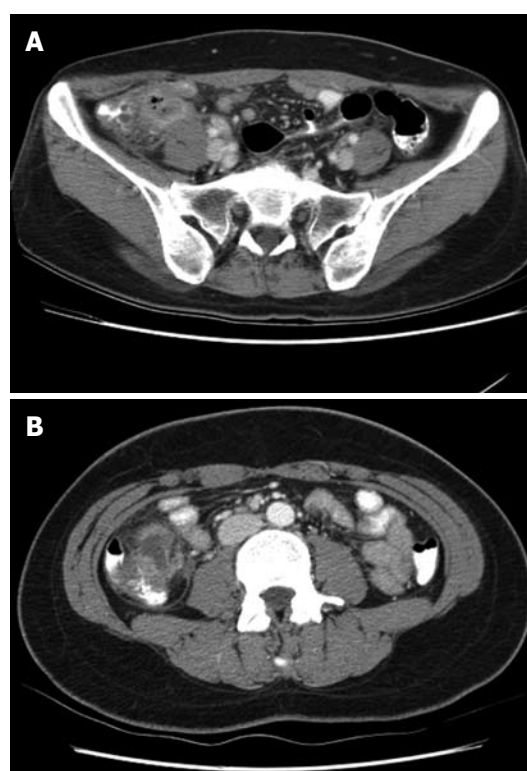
Radiologic evaluation of acute cecal diverticulitis (computed tomography). A: Inflamed diverticulum; B: Diverticulitis with phlegmon.
